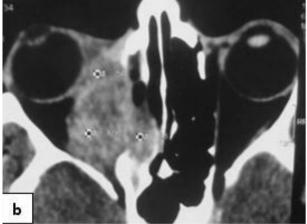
(a)- Clinical features of aspergillosis: proptosis and lateral displacement of right eye with fullness over right superior sulcus. (b)- CT scan (axial section) of the orbits shows opacification of the paranasal sinus with bone erosion and medial orbital involvement (right side).
